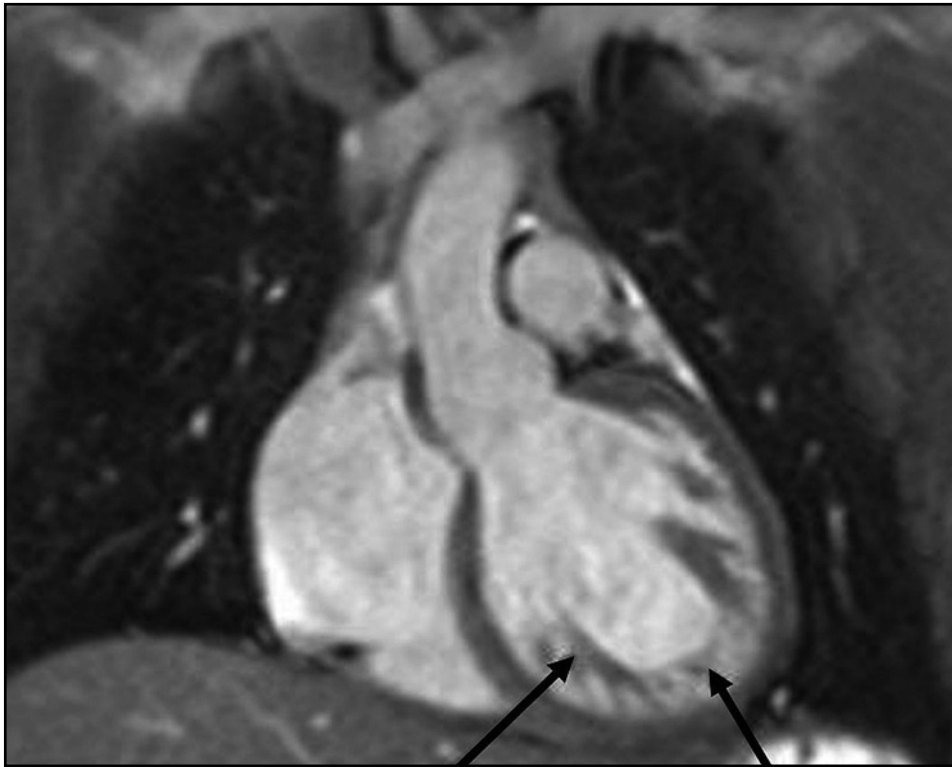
Cardiac magnetic resonance imaging of the non-compacted (arrows) and compacted segment in left ventricular wall (long axis view). Coronary trifurcated FISP (bright blood sequence).
